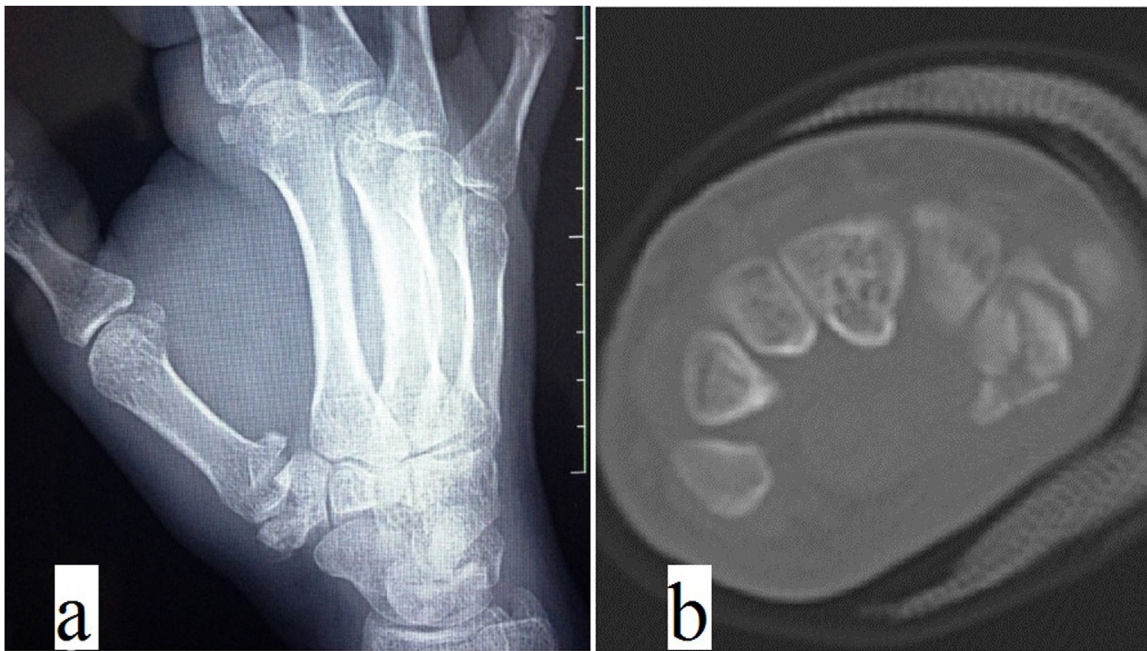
Preoperative radiograph and CT scan images show the comminution of trapezium fracture.
